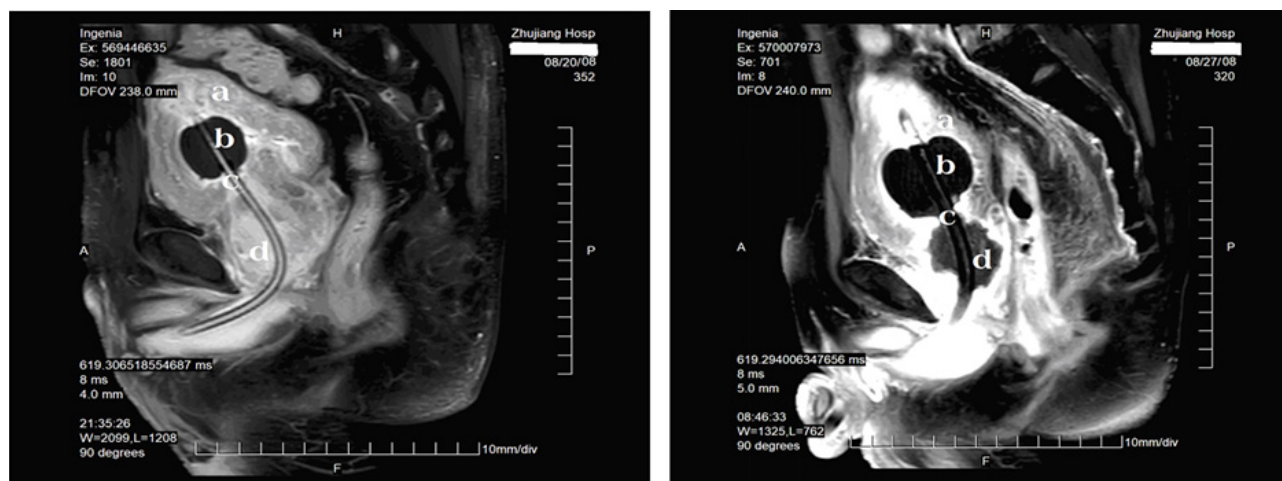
MRI images of the preservation of the bladder neck before and after B-TUERP for BPO.
